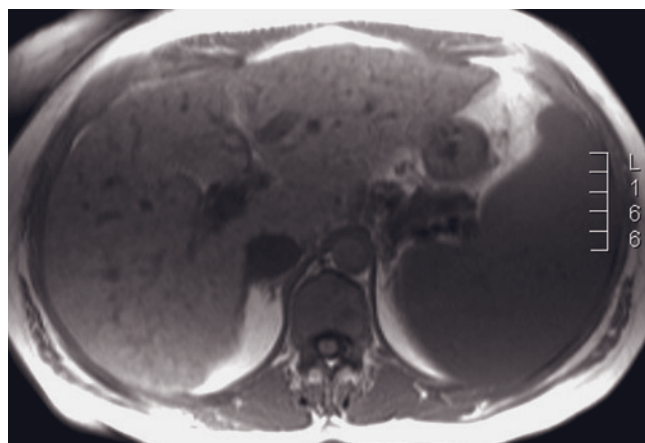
(Continued) postgadolinium SGE images; fat-suppressed T2-weighted SS-ETSE (b), SGE (i), and immediate (j) and 90-s fat-suppressed (k) postgadolinium SGE images.
